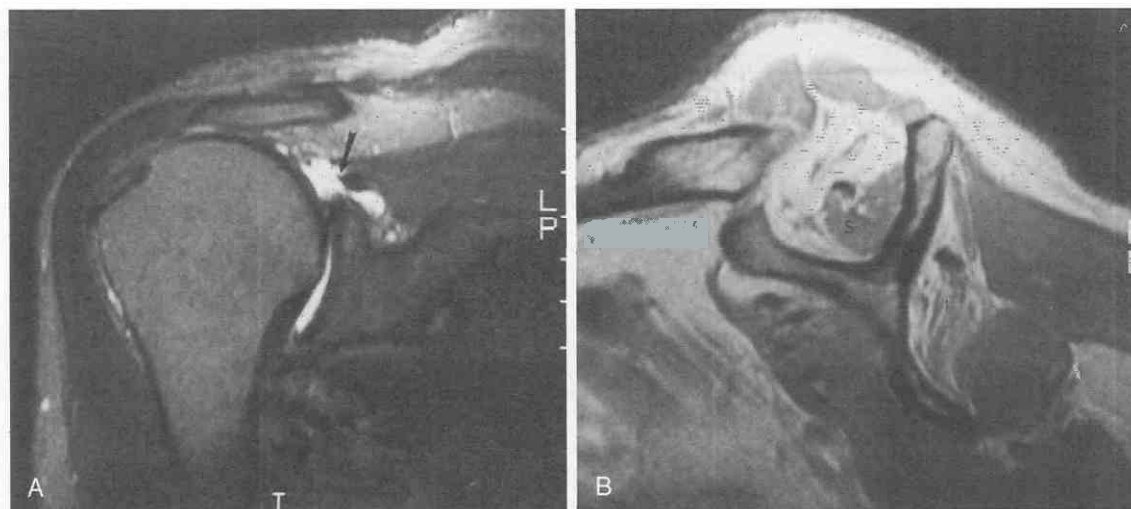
Atrophy. *A*, T2-weighted (TR = 2500 msec, TE = 70 msec) coronal oblique image. The supraspinatus muscle and tendon are retracted to the glenoid (*arrow*), and the humeral head contacts the acromion. *B*, Proton-density-weighted (TR = 2500 msec, TE = 14 msec) sagittal oblique image. The supraspinatus (S) and infraspinatus (I) muscles are markedly atrophied and infiltrated with fat.
